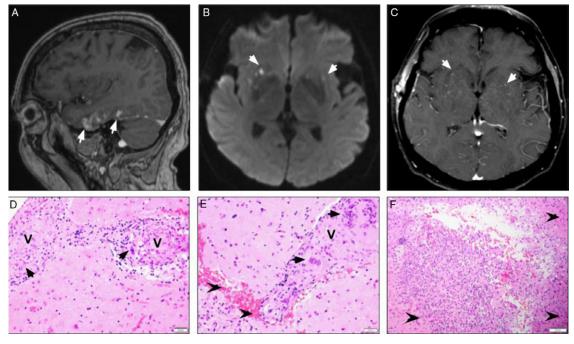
MRI and right temporal biopsy pathology images.
